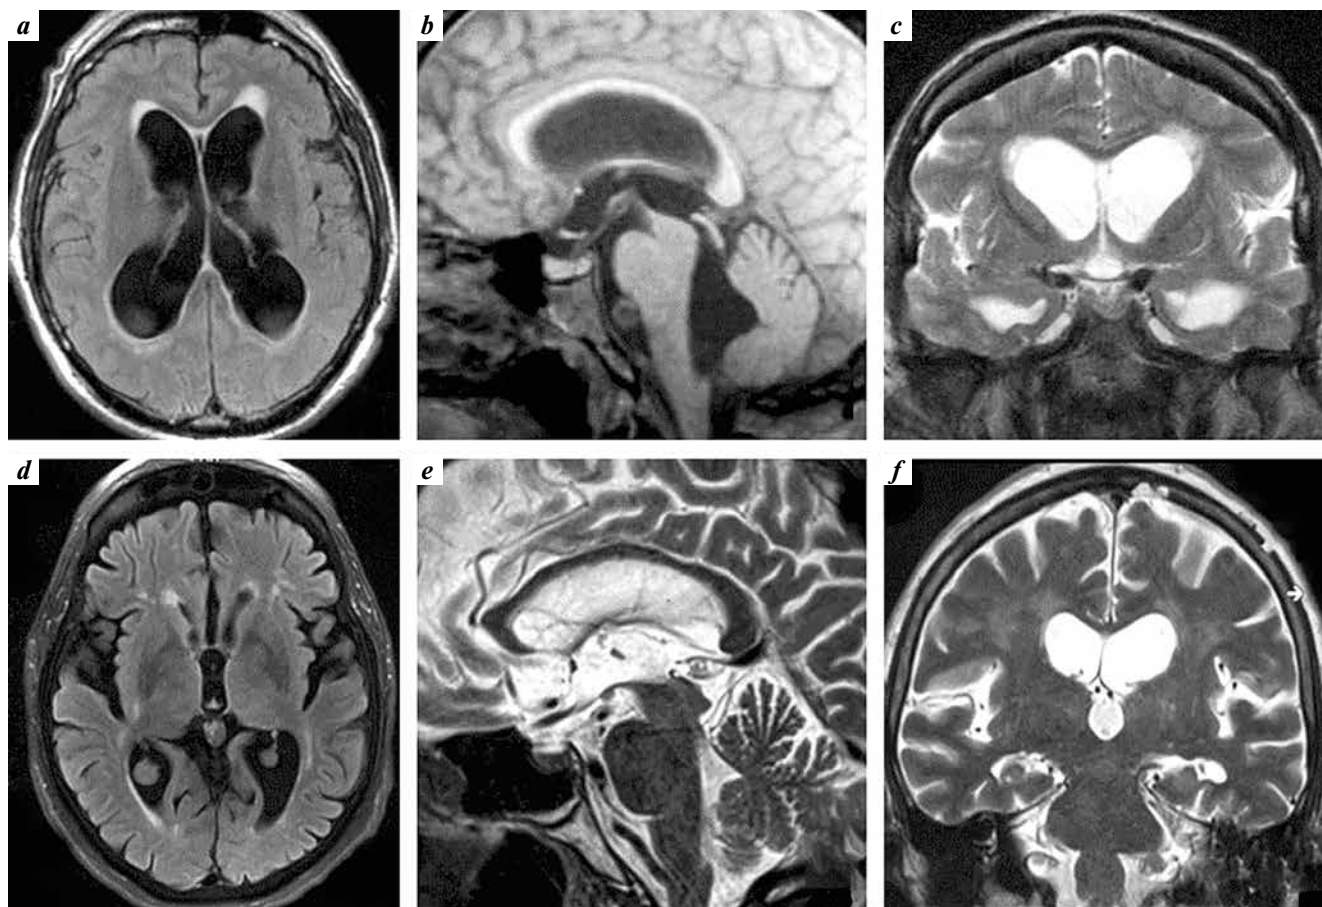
Hydrocephalus with DESH-symptom (AH4). Lateral ventricles and 3<sup>rd</sup> ventricle are enlarged (a, d). Sizes of the 4<sup>th</sup> ventricle close to normal (c). Premamillary membrane has a normal position, aqueduct and 4<sup>th</sup> ventricle outlets are free, that's confirmed by the "flow void" on the T2 scan (c). Frontal T2 shows a significant expansion of the lateral fissures, while subarachnoid spaces of the parasagittal and interhemispheric regions are compressed. Hyperintensive periventricular, subcortical and brain stem signal T2 and FLAIR (a, b, d)
